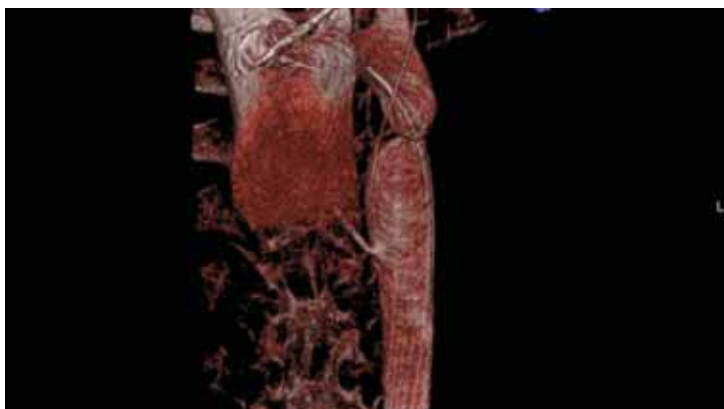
Fluoro CT scan of an aortic coarctation with a stent graft being positioned within the stenosis.
